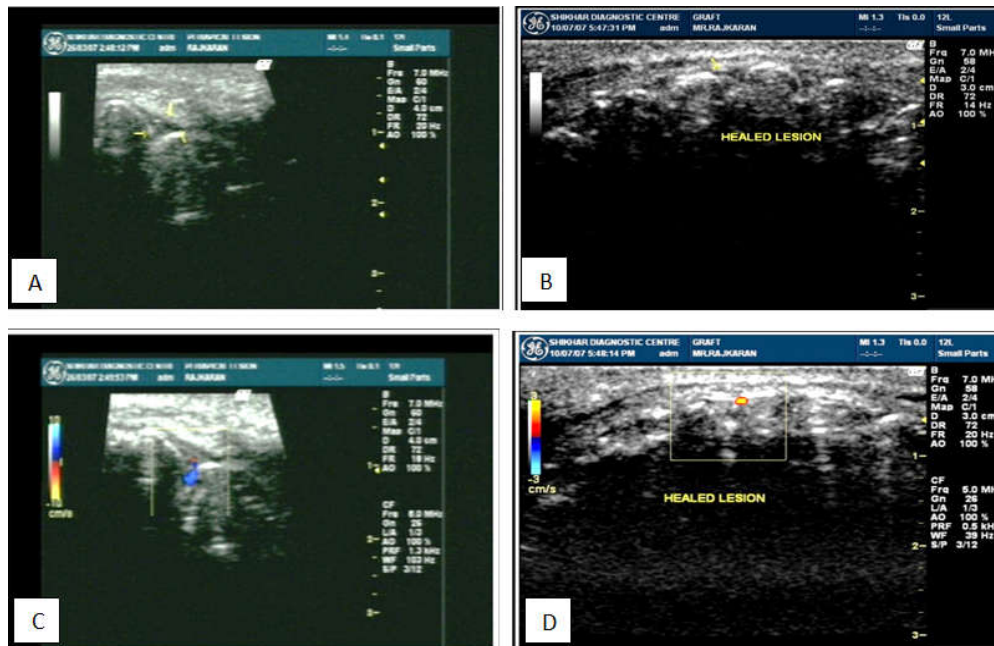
A & B Ultrasonographic examination A. Preoperative examination B. Postoperative 12 weeks. C & D Color Power doppler examination. C. Preoperative. D. Post operative 12 weeks
